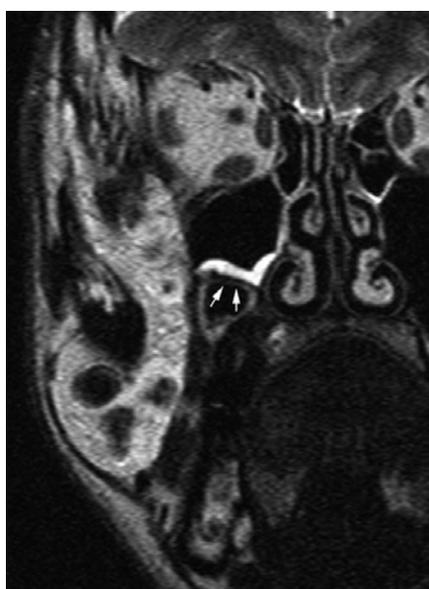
Masticator space hemangioma appears hyperintense on fat-saturated axial T2-weighted sequences, extending around masticator muscles. a A double posterior sinus wall with a sharp boundary (arrows) is apparently subdividing the maxillary sinus into an anterior hyperintense and posterior hypointense compartments. b The double posterior sinus wall sign is related to upward displacement of the sinus floor by a radicular cyst
